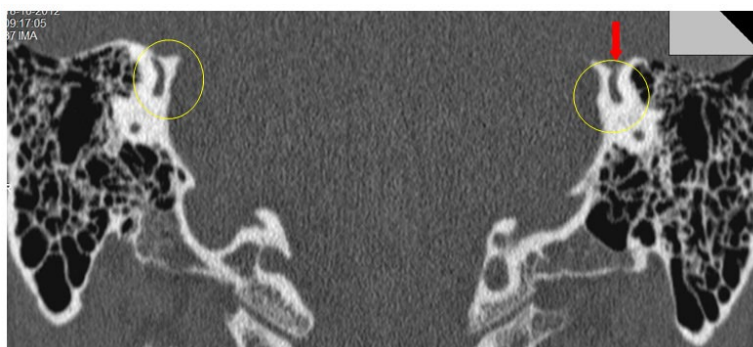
HRCT Temporal Bone showing coronal cuts. Yellow encircled region shows superior semicircular canal of both sides. Red pointing arrow shows dehiscence in left superior semicircular canal.
